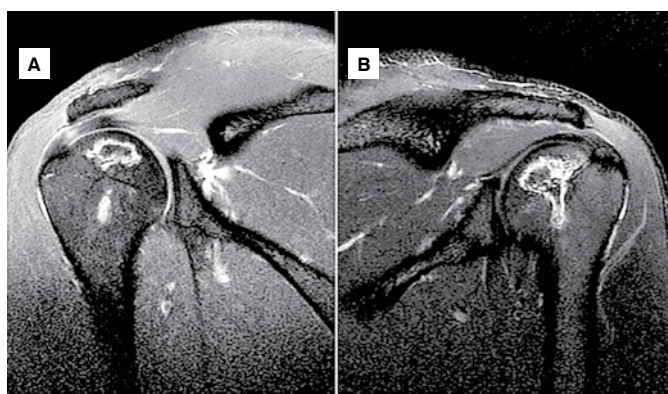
MRI of the shoulders showing bilateral involvement without joint collapse: (A) right, (B) left.
